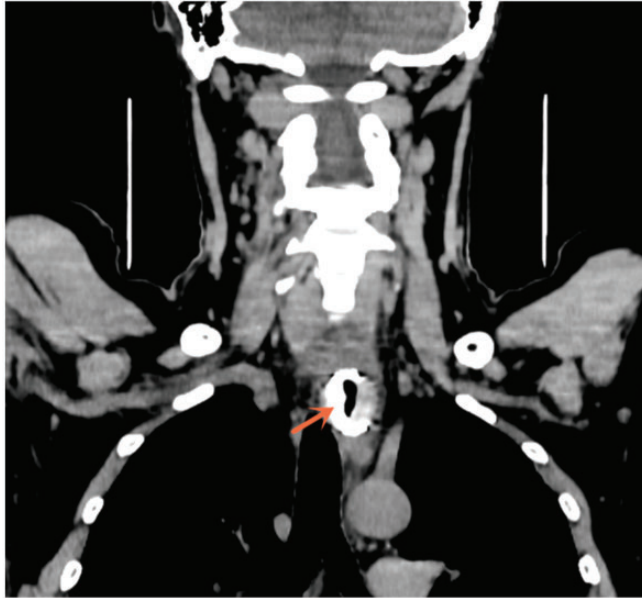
Computed tomography scan of esophagus showing an impacted foreign object (arrow) in the esophageal lumen.
